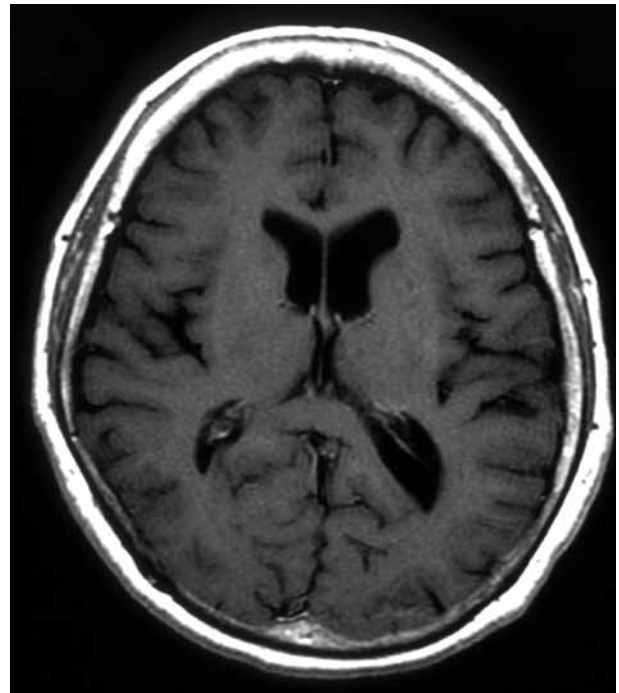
Axial T1-weighted MR image demonstrating disappearance of the hydrocephalus.
